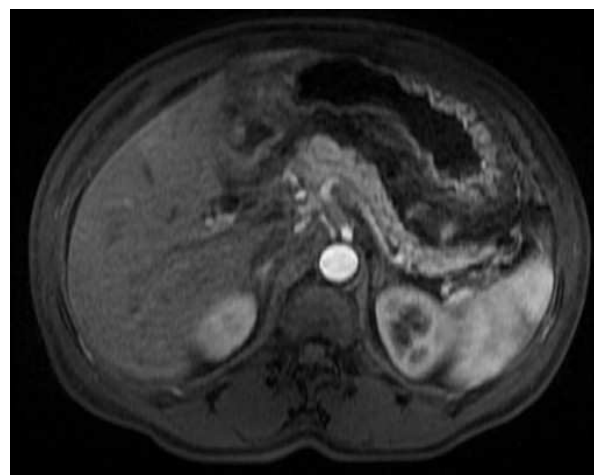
MRI of the abdomen with contrast (Case #3).
